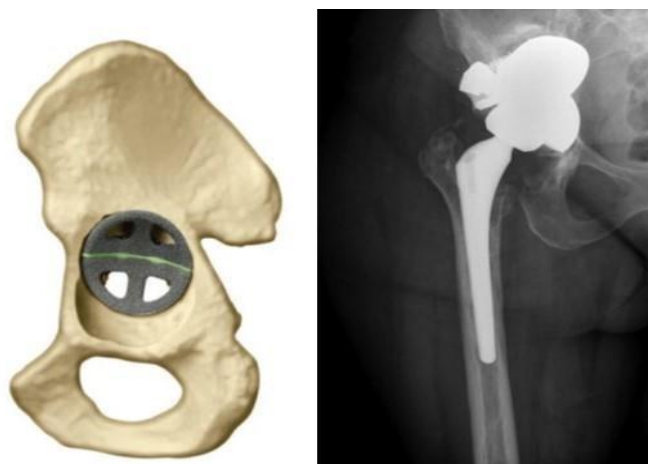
Footing position. Algorithmic and postoperative X-ray ⁽⁷⁴⁾.
